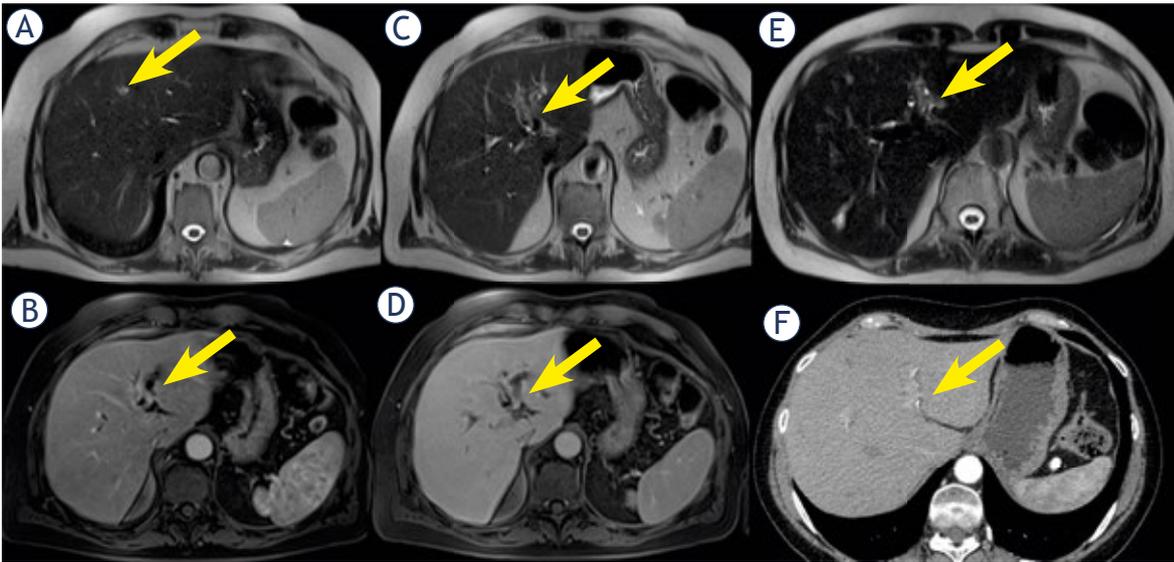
Man 51 y with p-Net and peribiliary metastasis. The lesion is hyperintense (arrow) in T2-W sequences (A, C, E) with progressive contrast enhancement (arrow) during contrast study (B, D, F) both in MR and in CT.
